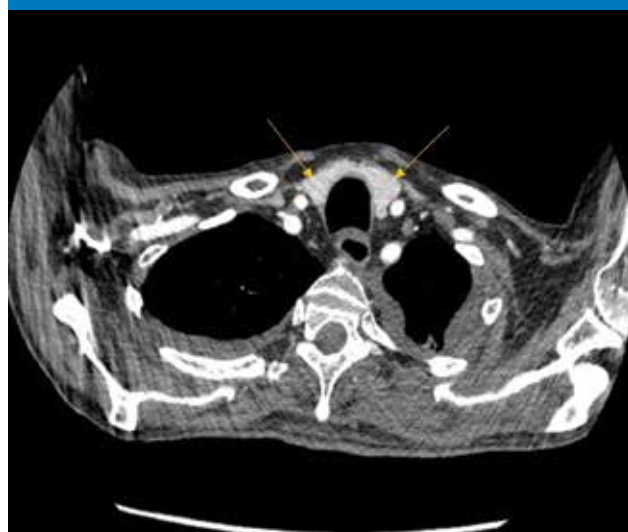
Computed tomography of the neck denoting low-density areas (yellow arrows) of the right thyroid gland lobe and inferior left lobe.
